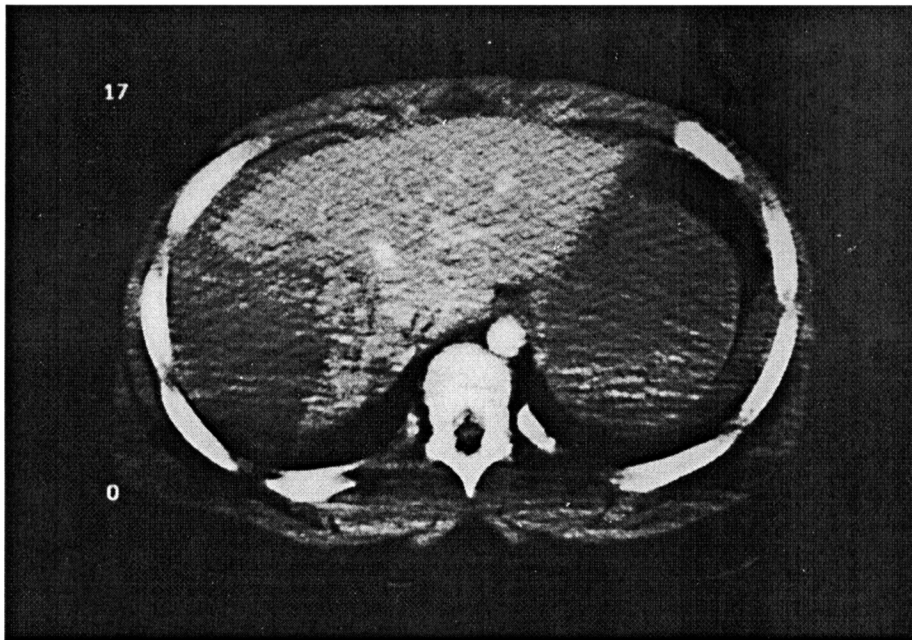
Initial CT scan depicting a severe right lobe hepatic injury.
